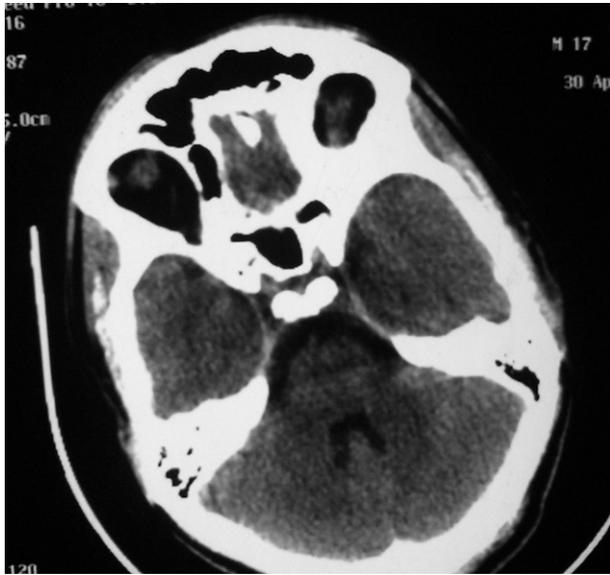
Initial plain CT brain.
